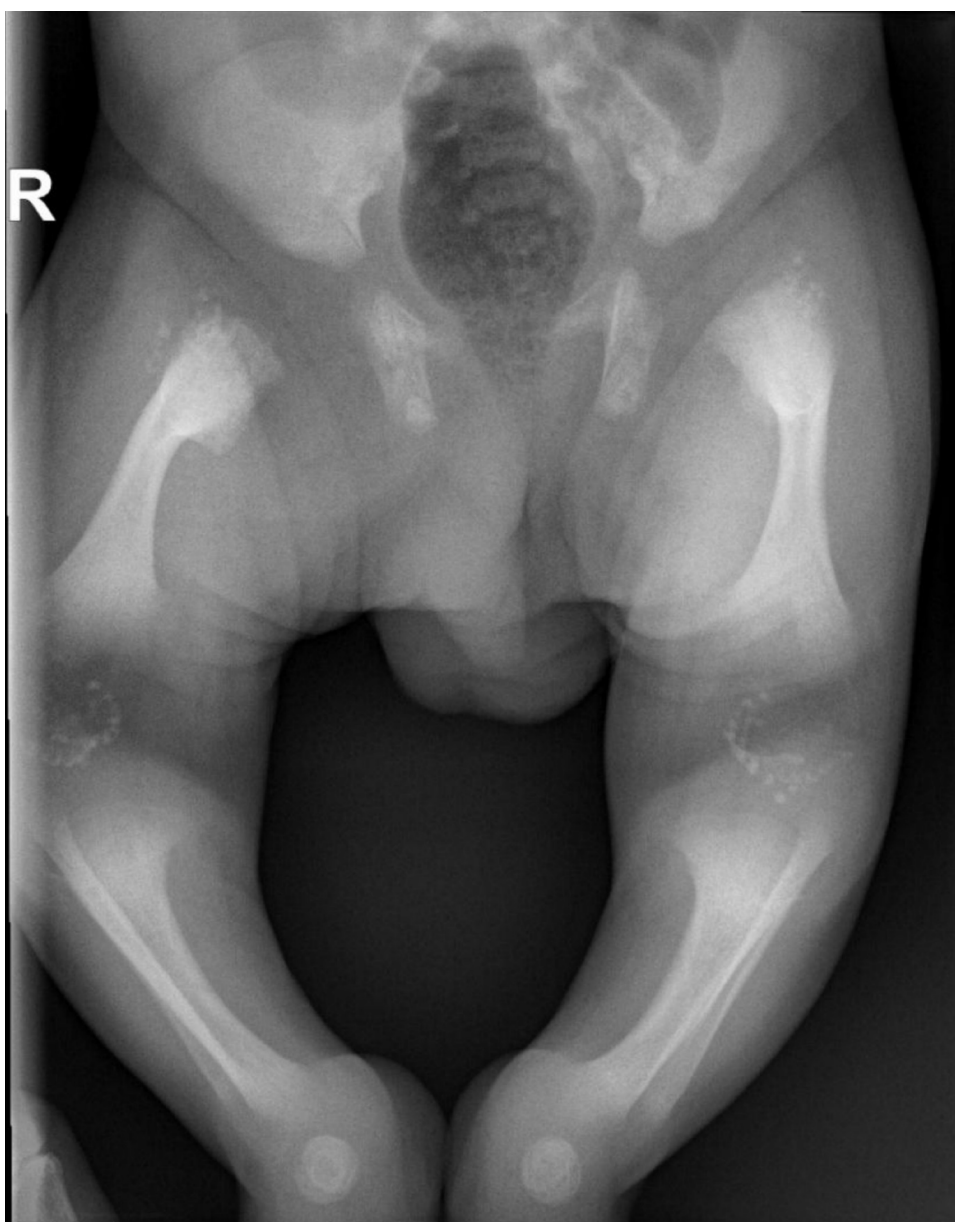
Skeletal radiograph shows bilateral short femurs, widened epiphyses, punctate calcification, and acetabular dysplasia.
